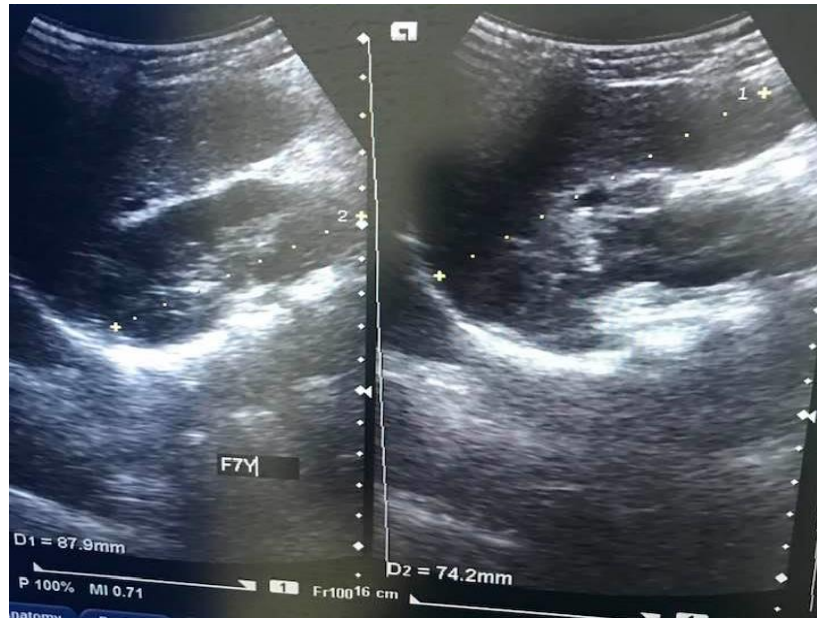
Sonogram of left kidney and spleen lengths of 7year female child
